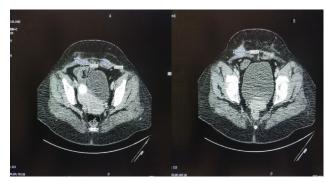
a-b: Multi-focused nodular hyperdense lesions seen in CT
